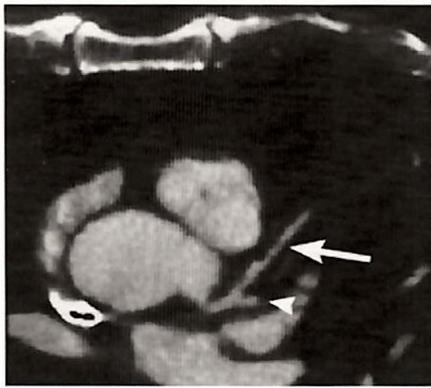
Coronary CT angiography with electron-beam computed tomography.
